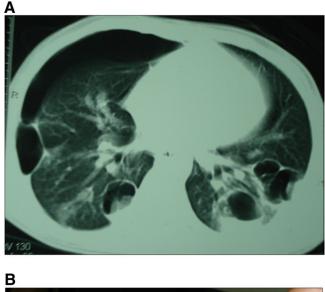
A, Multiple bullous lesions suggestive of *S aureus* infection were evident in lung computed tomography. B, Postsurgical picture of the child's left forearm demonstrating the extension of the lesion.
